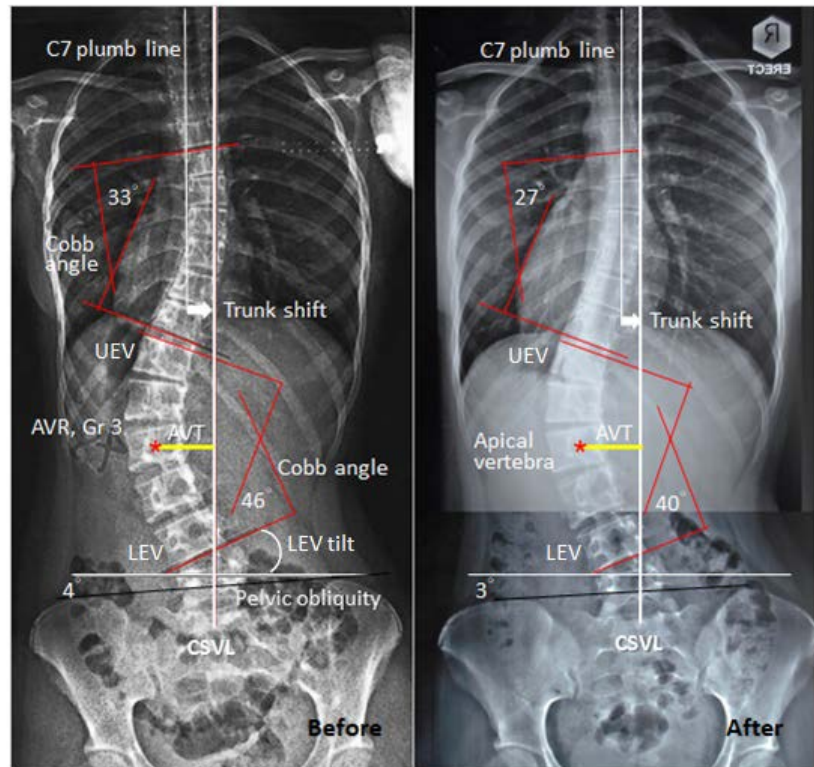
Comparison of pre- and post-treatment radiographs of a 16-year-old girl (Case 9) who had failed to achieve a response from bracing for one year before chiropractic intervention. Following 13 months of chiropractic manipulation, improvements in spinal morphologies were observed.
